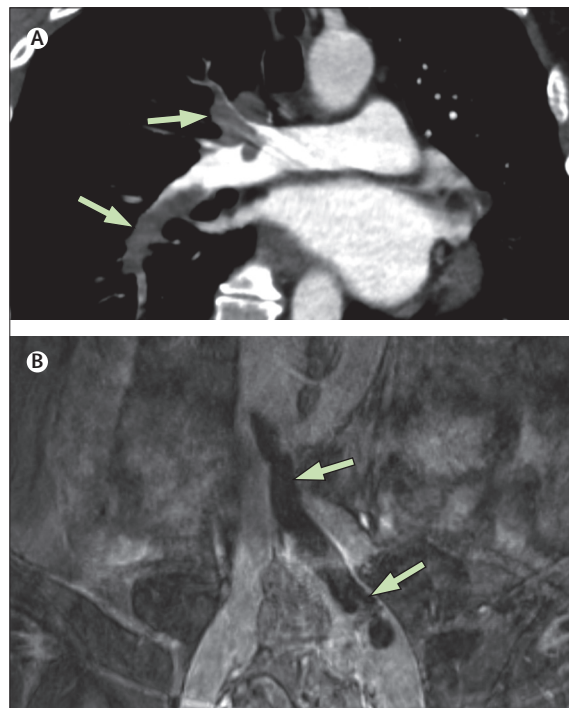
Thromboses and thrombocytopenia after ChAdOx1 nCoV-19 vaccination. CT pulmonary angiography shows a central pulmonary embolism (arrows; A). Magnetic resonance venography shows a venous thrombus in the left internal iliac vein—including the common iliac vein—with extension into the inferior vena cava (arrows; B).
